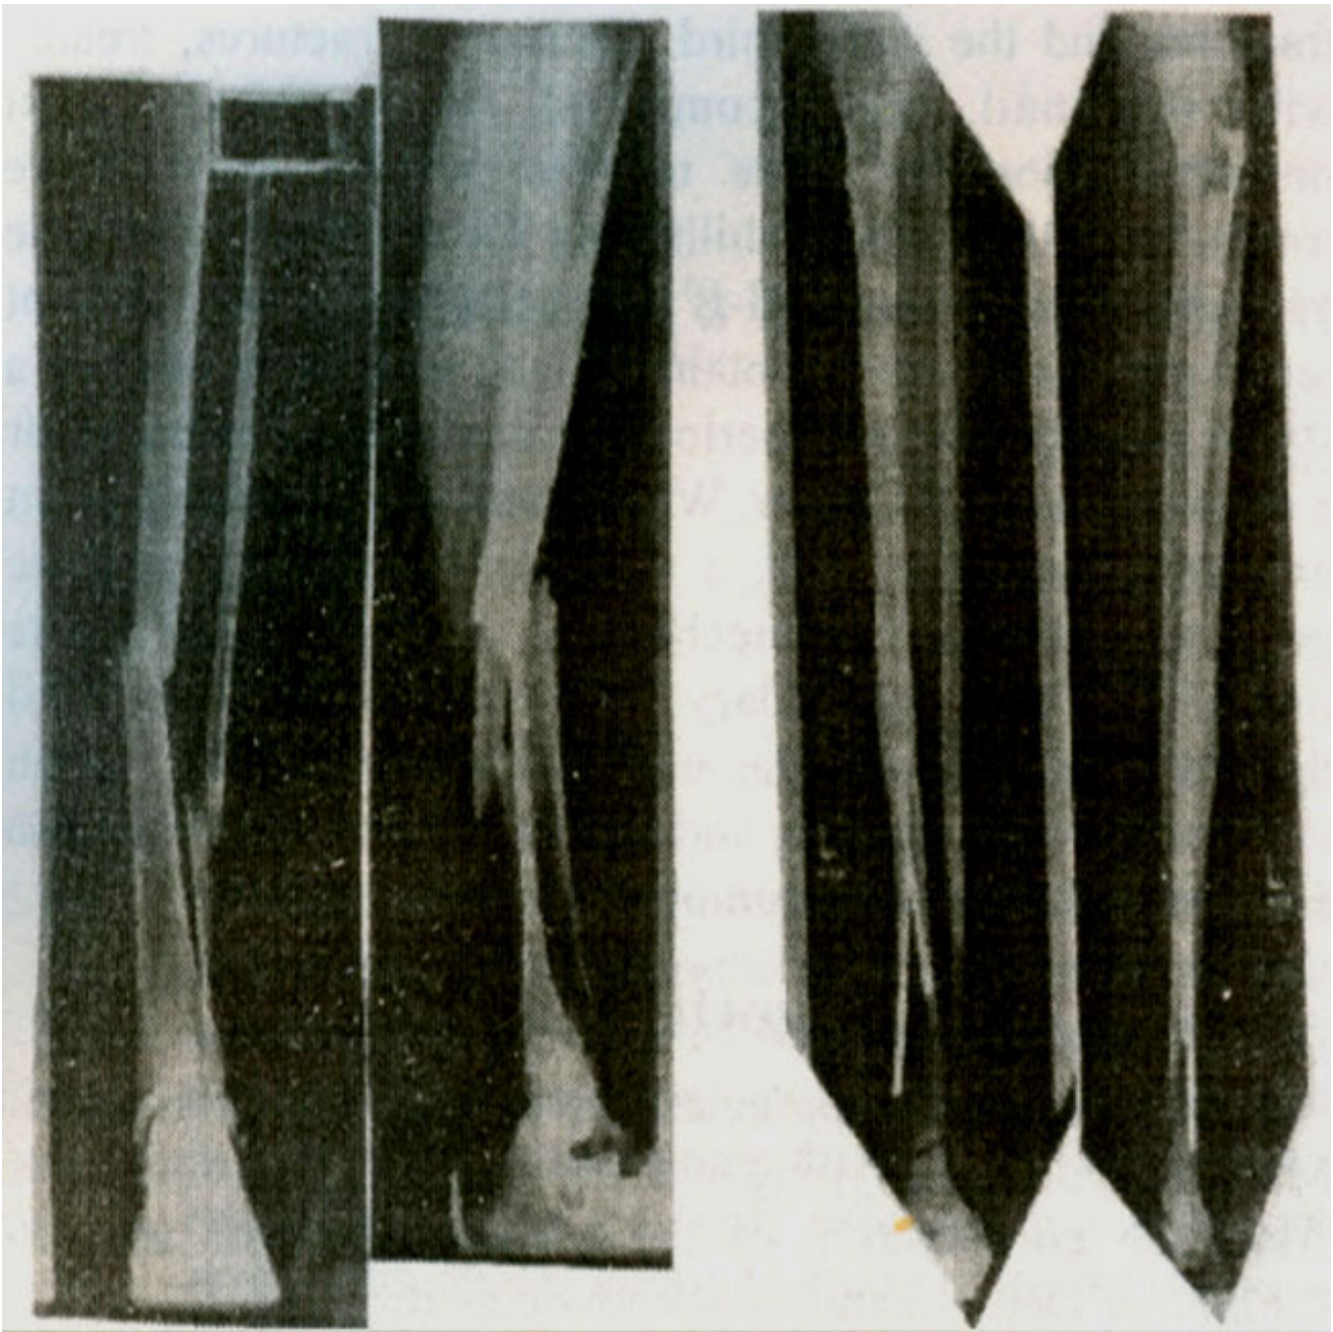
Clinical radiograph (A) AP and (B) lateral, of a 25- year old man with a grade I, OTA 1A open tibial fracture. Ender nails were inserted. Approximately two years after the injury the fracture site is noted to have consolidated (C) and (D).
